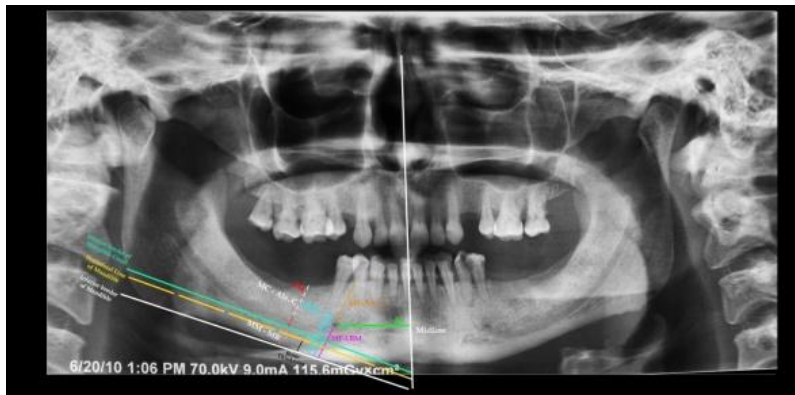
Measurements on the panoramic radiograph. Mandibular bone measurements were made as follow; Horizontal line of mandible, Line parallel to long axis of mandible and tangential to inferior border of mandible was drawn. UMBV-LBM, Line perpendicular to this tangent intersecting inferior border of mental foramen was constructed, along which the following measurements were made: MC-Alv. C, Lower border to top of alveolar crest: total height of the mandible; MF-LBM, distance from lower border to inferior edge of mental foramen: basal height; bone thickness of mandibular cortex (So, in our study we measured the (bone thickness) of the mandibular cortex). These measurements were made on both sides of the mandible.
